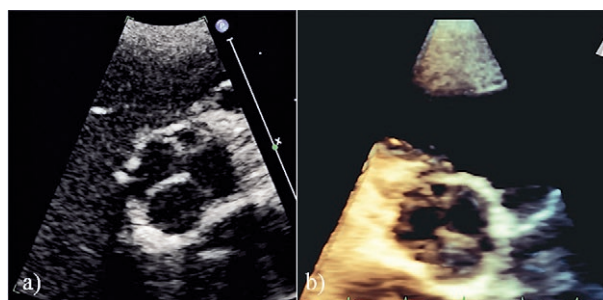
a) Transthoracic echocardiographic study showing the QAV of case 2, B type; b) 3D echocardiographic reconstruction of the QAV.
